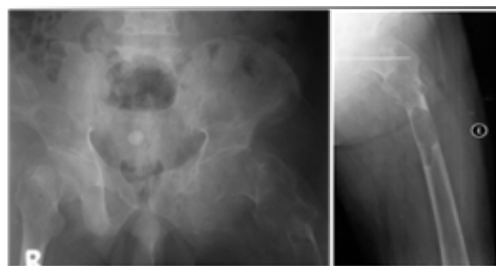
a. Pelvic x-ray ; b. Left Femur X-ray, both a and b showed pathological fracture of the left proximal femur
